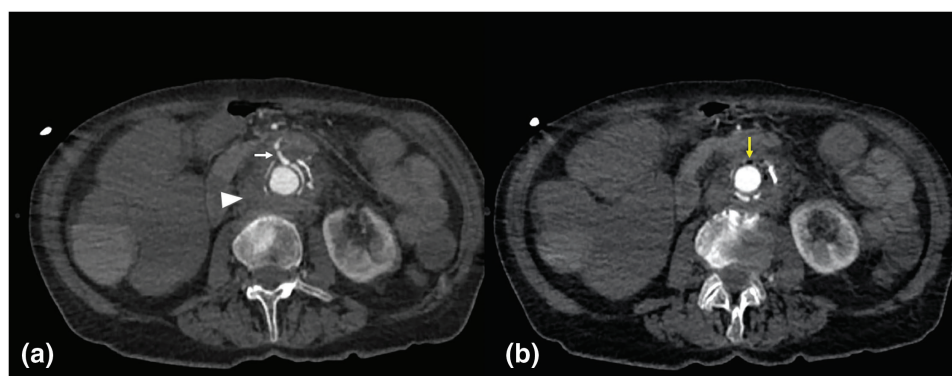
Computed tomography angiography (CTA), axial planes, arterial phase: in (a) a direct connection between the abdominal aorta and the III duodenal portion can be noted (white arrow) in the context of severe periaortic adipose tissue thickening (arrowhead) due to infection of the previous aorto-aortic graft. (b) Aerial nuclei in the aortic lumen can be seen (yellow arrow).
